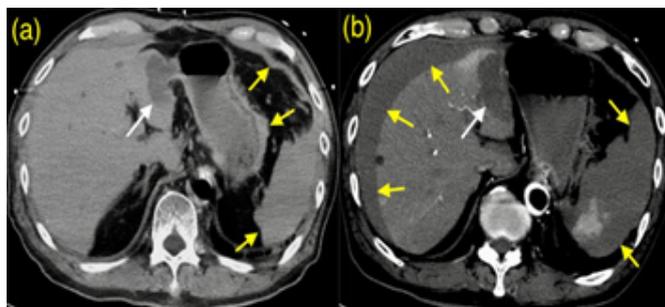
5a: Plain abdominal computed tomography (CT) performed after percutaneous coronary intervention (PCI); 5b: Enhanced abdominal CT performed 4 hours after PCI. The hepatic cyst had ruptured (white arrows) and a hematoma developed rapidly (yellow arrows).
